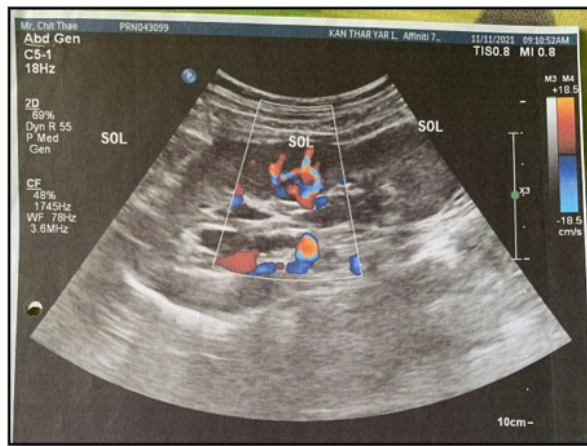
Ultrasound of graft kidney showing space occupying lesion.
